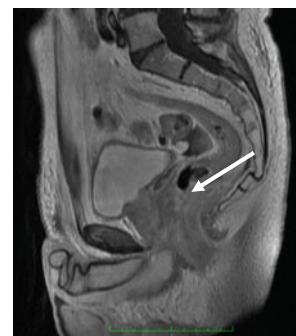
Contrast-enhanced magnetic resonance image of primary low rectal gastrointestinal stromal tumor before (*right*) and after (*left*) preoperative imatinib for 8 months. Because the tumor harbored an exon 9 mutation, the patient was treated with a higher dose. Surgery consisted of local excision rather than a formal low anterior resection
